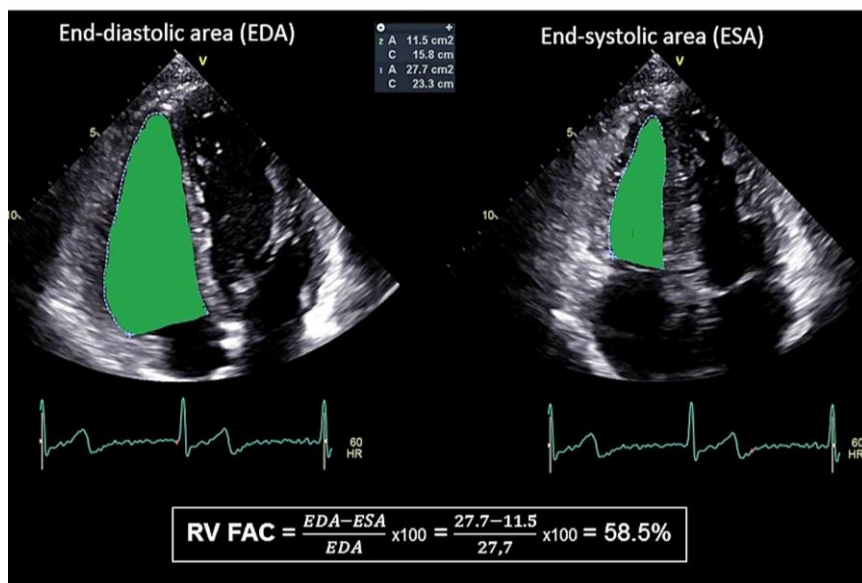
Assessment of right ventricular (RV) fractional area change (FAC) by 2D echocardiography.
